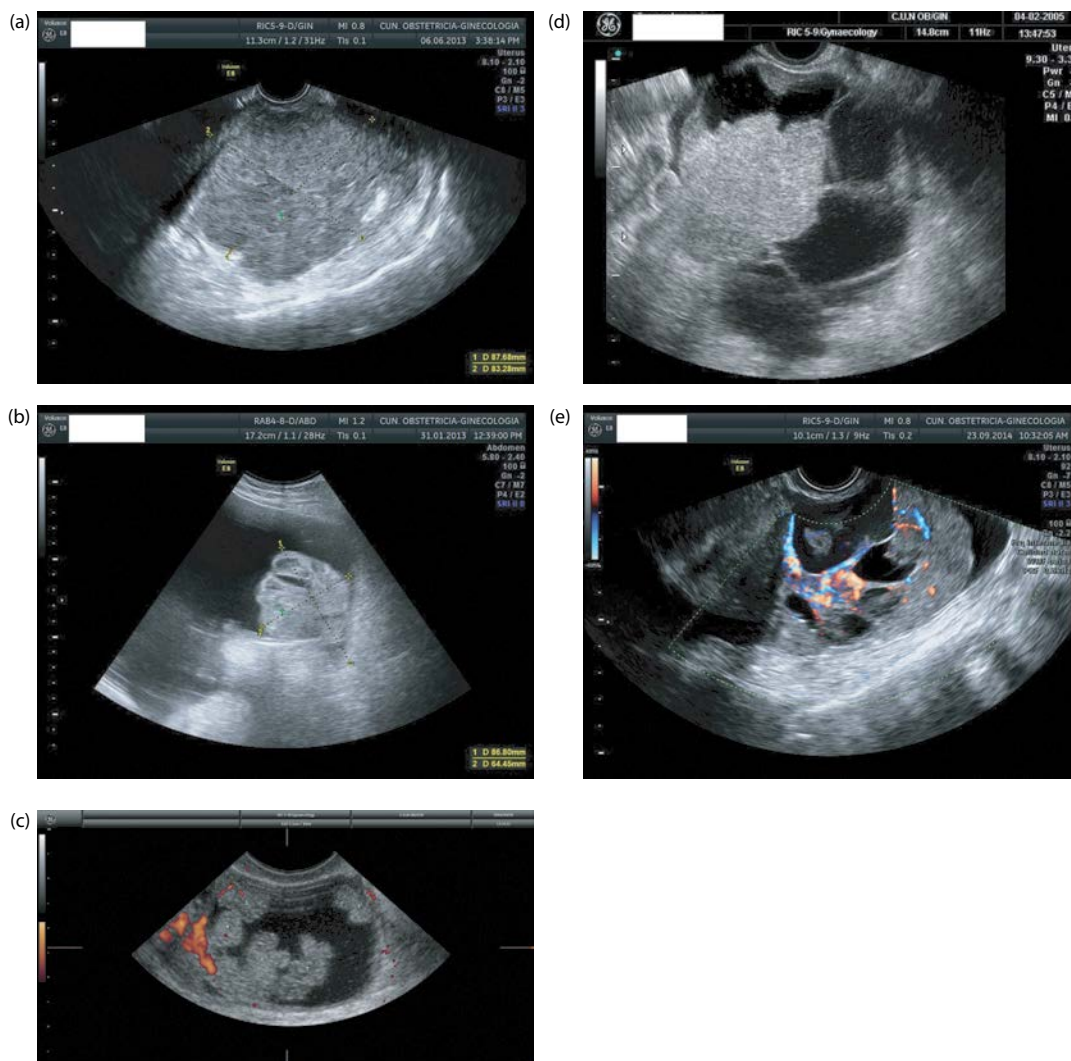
Examples of ultrasound features of IOTA simple rules. (a) M1 (irregular solid tumor); (b) M2 (presence of ascites); (c) M3 (at least four papillary projections); (d) M4 (irregular multilocular-solid tumor >100 mm); (e) M5 (color score 4). (Continued)
